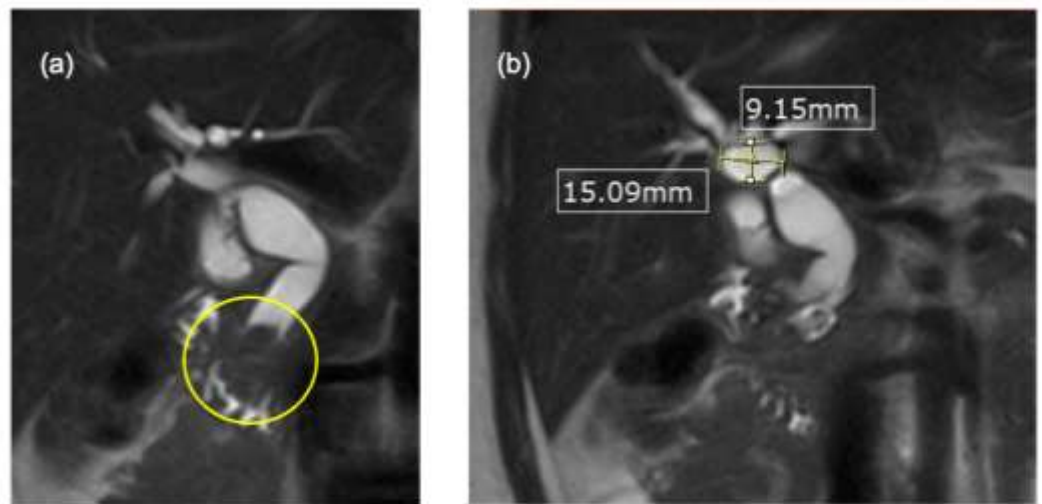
Contrast-enhanced abdominal MRI
